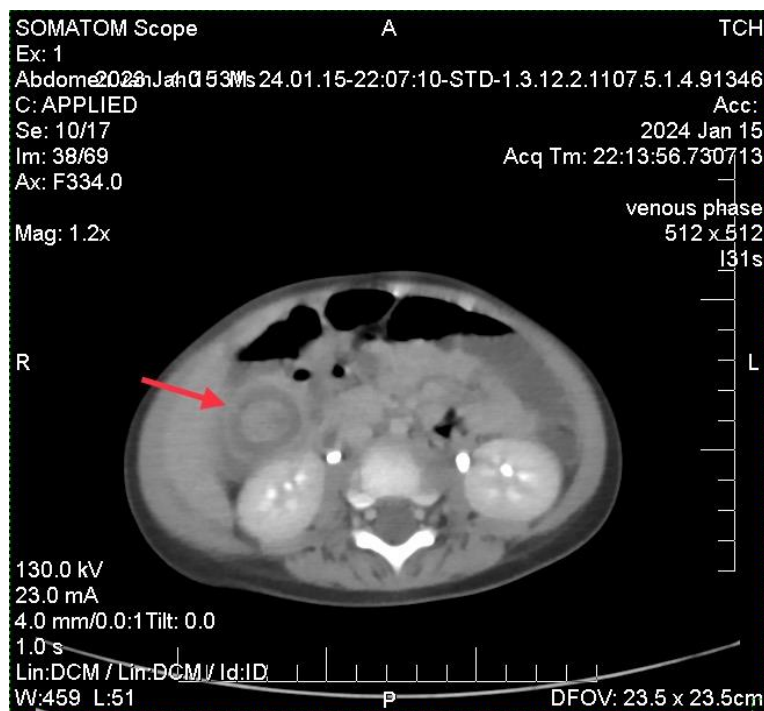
CT scan of the abdomen reveals target sign (red arrow) .
